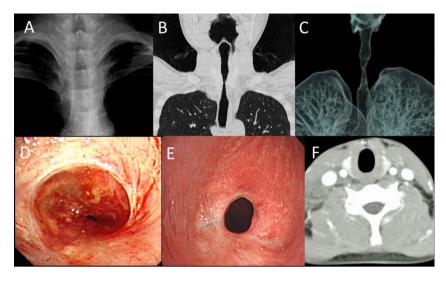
(A) Chest radiograph 90 days after injury showed upper tracheal stenosis. (B) Chest computed tomography (CT) on admission demonstrated a long segmental stenosis below the vocal cords. (C) The stenosis was visualized with a three-dimensional CT on admission showing a bottle neck pattern with a length of 27 mm. (D) Bronchoscopic findings of emergency tracheotomy showed a pinhole stenosis with adhesion and deformation of tracheal cartilage. (E) Airway patency was confirmed by bronchoscopy 6 months after surgery. (F) The initial CT taken at the previous hospital showed tracheal swelling at the upper area of the stenosis.
